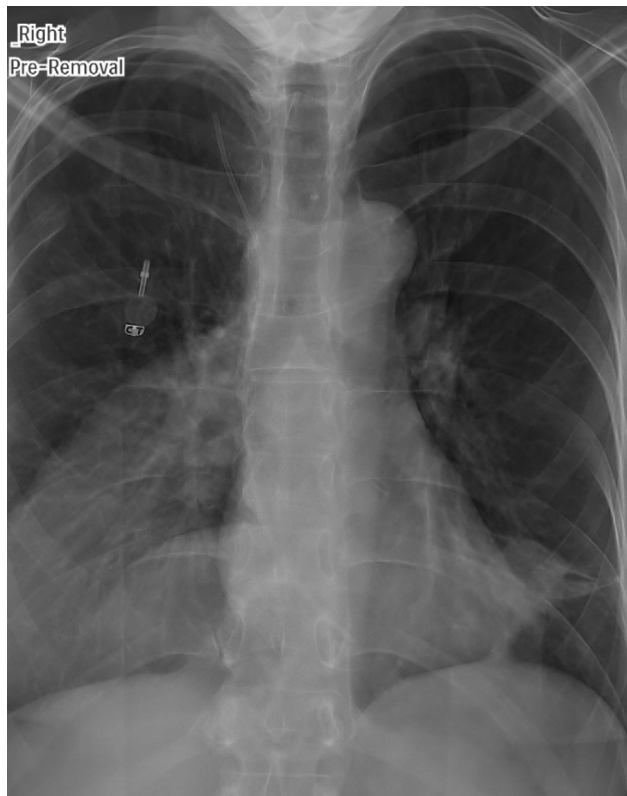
Frontal chest radiograph depicts the chest wall port chamber with its catheter detached and dislodged, one end of which is seen in the SVC and the other projected over the proximal right ventricle.
